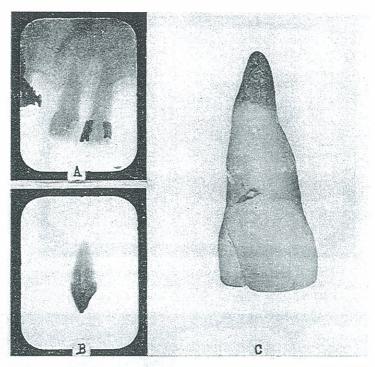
Comparison of Roentgenographic and Photographic views of an incisor.
